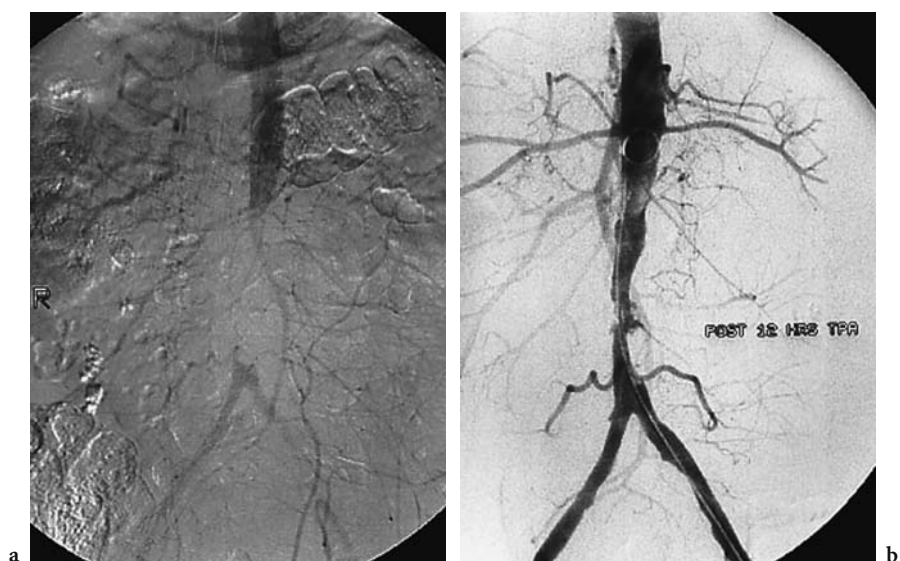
IVDSA (a) demonstrates aortic occlusion in a 76-year-old patient causing acute limb ischaemia. The patient was in sinus rhythm and had no previous cardiac history. An echocardiogram was normal. It was assumed that the occlusion occurred secondary to aortic plaque rupture. Following 12 h of thrombolysis the aorta was patent though clearly diseased (b). The segment was then treated successfully by stent insertion (c)
